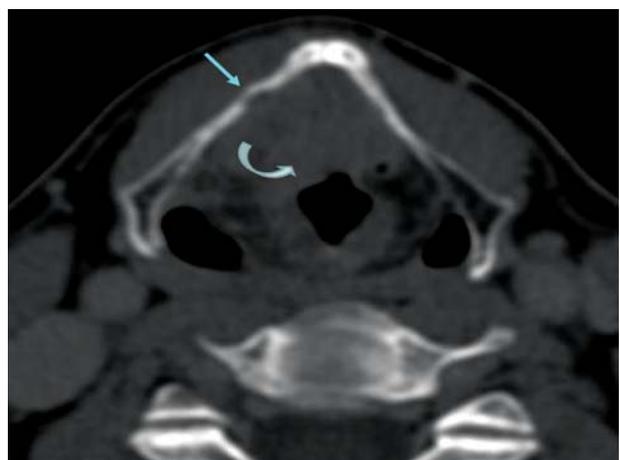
Cartilage erosion-Axial CT scan viewed at bone window settings reveals erosion of inner cortex of right thyroid lamina (arrow) in a case of supraglottic carcinoma (curved arrow)
